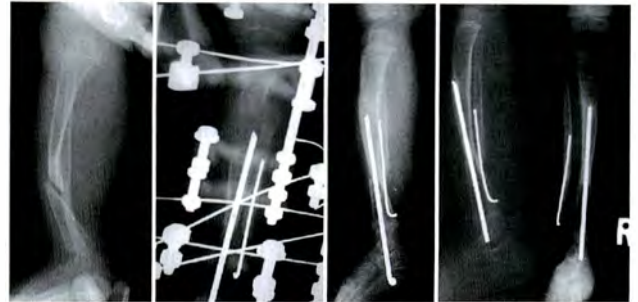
Serial Radiograph of patient 5
